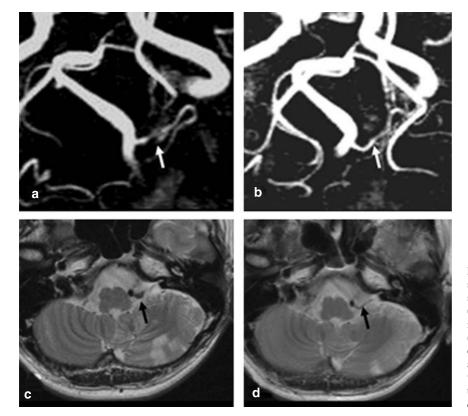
MRA at one month after the onset showed fusiform dilatation of the proximal segment of the PICA with an intimal flap (a: arrow). Similar findings were detected in T2-wighted MRI at 2 weeks after onset (c: arrow). Spontaneous resolution of the dissecting aneurysm was shown by MRA at 10 weeks after onset (b: arrow). T2-weighted MRI at 5 months after onset detected no recurrence of the aneurysm (d: arrow)
